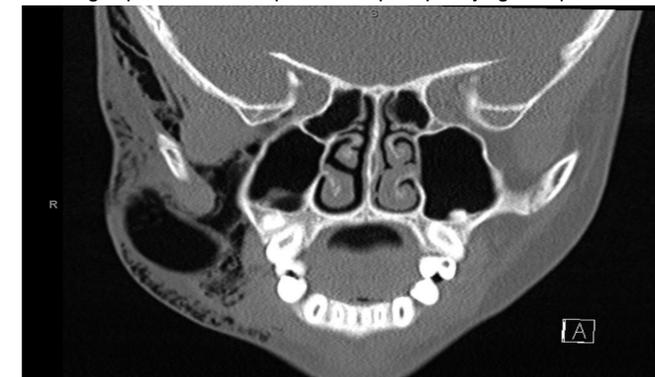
Coronal CT scan showing subcutaneous free air in the right temporal, parapharyngeal and buccal spaces.
